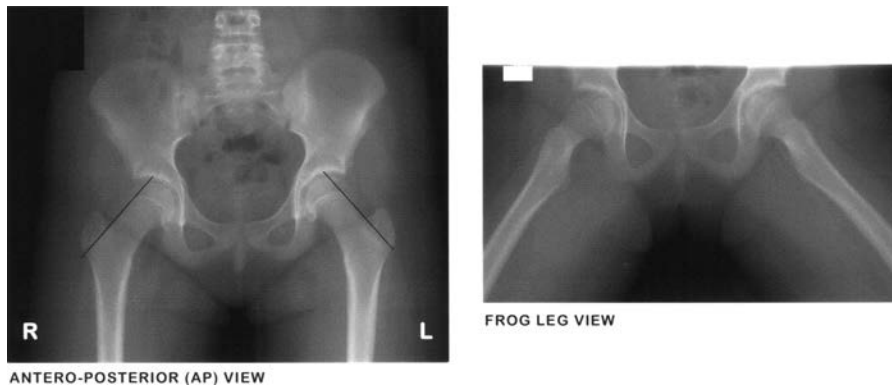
Hip radiographs in a 13-year-old girl with mildly slipped capital femoral epiphysis (SCFE) on the right. Note on the AP view that a line drawn along the superior border of the femoral neck (Klein line) shows less femoral head superior to the line on the right than it does in the normal hip on the left.
